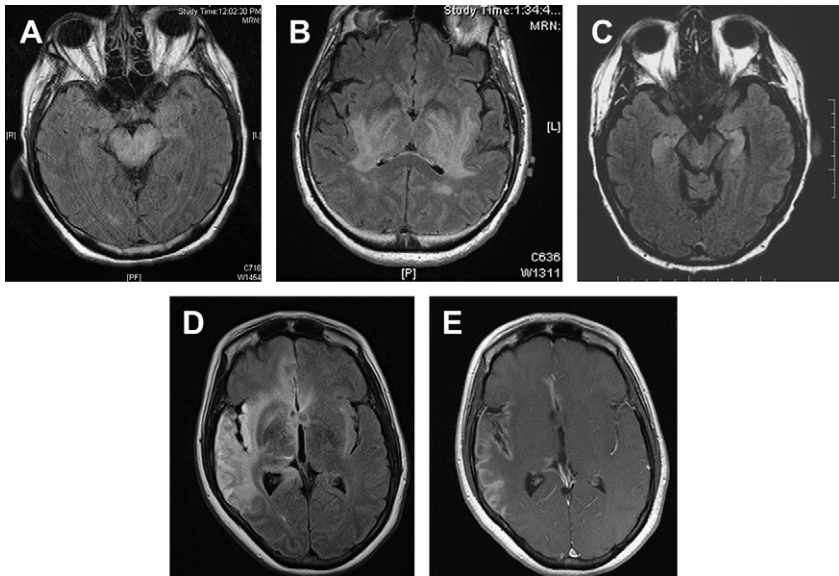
MRI patterns of viral encephalitis. Although not definitive for specific pathogen and, in fact, as shown in panels *D* and *E*, sometimes misleading, MRI can be helpful. Different characteristic patterns in 3 patients show flavivirus (West Nile virus) or togavirus pattern of brainstem and basal ganglia pathology on FLAIR sequences (*A*, *B*) contrasted with HSV 1 encephalitis with bilateral hippocampal FLAIR abnormality (*C*); and FLAIR (*D*) and gadolinium-enhanced T1 sequences (*E*) of a patient thought to have HSV 1 but who had biopsy-proved varicella zoster virus encephalitis with small vessel vasculitis. There is extensive abnormal FLAIR signal in the right temporal and parietal lobes and genu of corpus callosum, along with sulcal increased FLAIR signal, suggesting proteinaceous fluid (*D*). Compared with the MRI with T1-weighted gadolinium images of *E*, cortical signal looked similar on T1 before gadolinium infusion (not shown), suggesting petechial hemorrhage.
